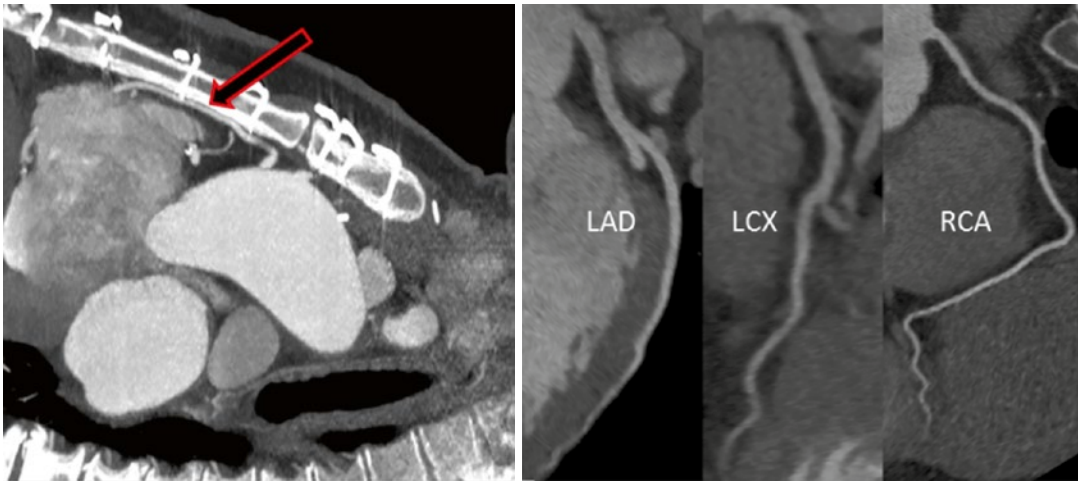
CTA applications: (Left) CTA of patient with previous CABG showing course of the saphenous vein graft to the right coronary artery (arrow) as it sits just posterior
